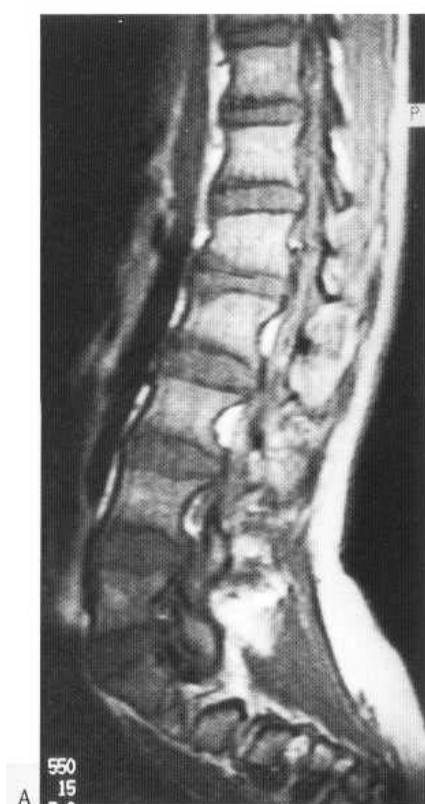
Achondroplasia. (A) This sagittal T1-weighted MR sequence shows vertebral scalloping as a prominent feature in the lumbar spine. (B) The axial image shows short, broad pedicles and severe associated canal stenosis.
